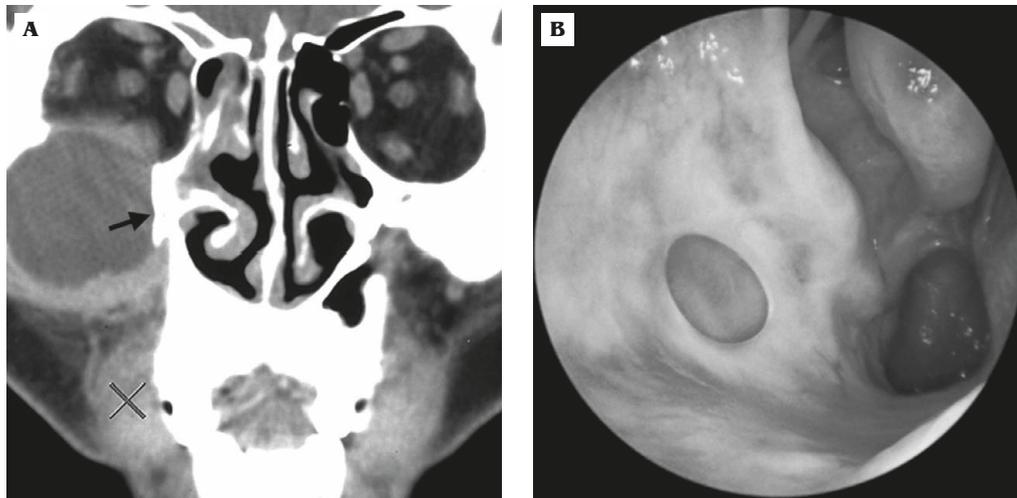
Preoperative computed tomography findings and the stoma of a mucocele treated by transnasal endoscopic surgery in a 40-year-old male. (A) Cyst with thickened bony medial wall adjacent to the inferior nasal meatus. (B) Stoma of the mucocele reduced 1 year after surgery.
